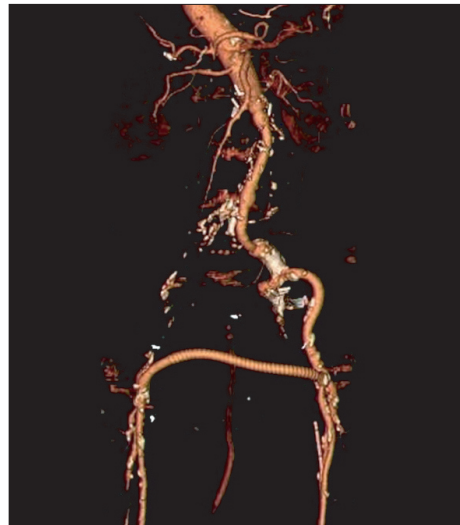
Follow-up computed tomography after aortic reconstruction.
